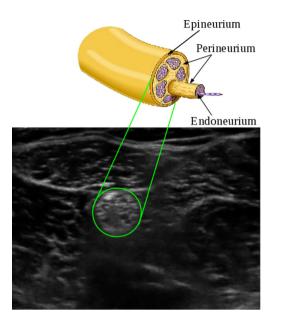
Popliteal nerve anatomy and appearance in the ultrasound image.
